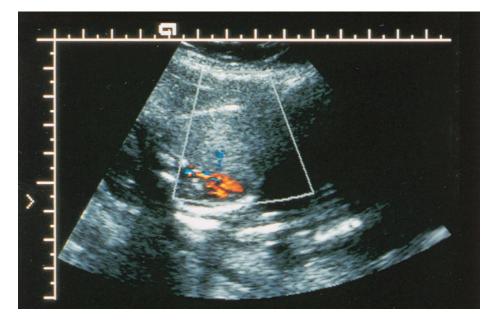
Ultrasound of the fetal chest at 23 weeks' gestation, demonstrating a homogeneous echodense triangular wedgeshaped thoracic mass, consistent with either type III cystic adenomatoid malformation or bronchopulmonary sequestration.
